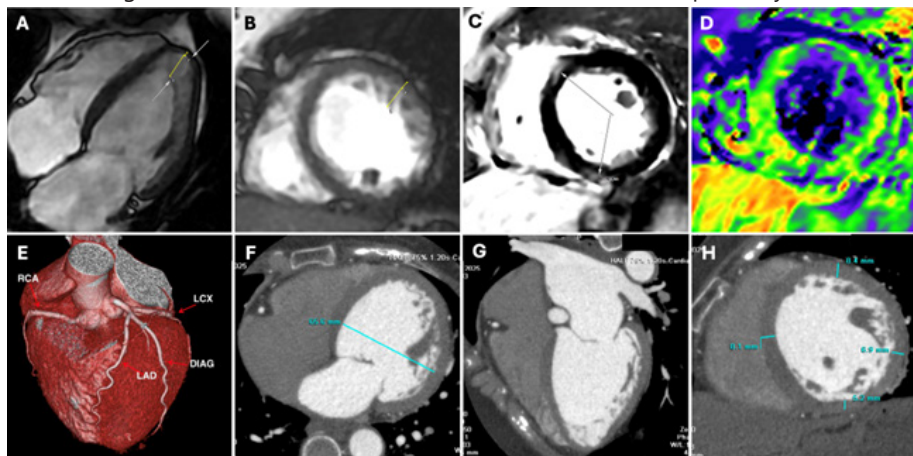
Cardiac magnetic resonance imaging (A–D) and coronary computed tomography angiography (E–H) of the patient. Prominent trabeculations were observed in the apical (A) and lateral (B) walls. The ratio of non-compacted to compacted myocardium was 3.2 in the lateral wall and 6.4 in the apex. Trabeculated LV mass/total LV mass was 25%. (C) Late gadolinium enhancement was detected in the mid-myocardium of the anteroseptal wall and in the basal-to-mid inferior wall. The scar mass was 2 g, accounting for 3% of the total left ventricular mass. (D) Prolonged myocardial native T2 was noted (native T2 = 59 ms). (E) Three-dimensional reconstruction of the coronary arteries showed no significant stenosis. (F–H) Left ventricular dilation with prominent trabeculations in the apical and lateral walls.
